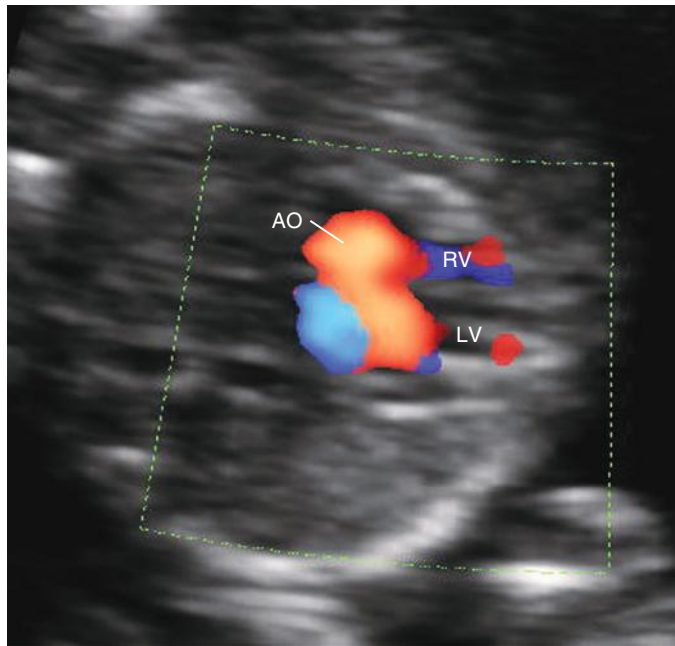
Color Doppler imaging demonstrates a five-chamber view in the first trimester of pregnancy; the aortic root is visualized arising from the left ventricle. AO, aorta; LV, left ventricle; RV, right ventricle.
